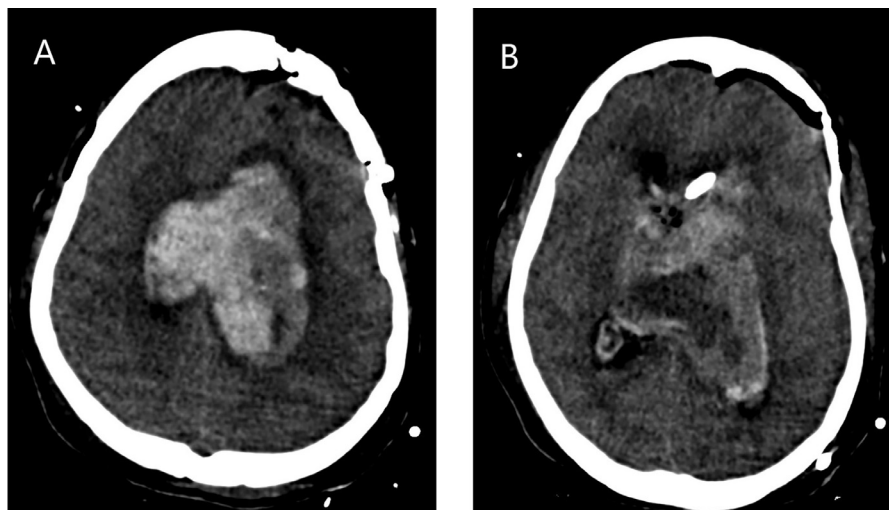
A and B one-day control brain CT: (A) periventricular hypodensity and effacement of sulci, consistent with increased intracranial pressure (A and B) Differentiating between blood products and remnants of the mass occupying the ventricle proves challenging.
